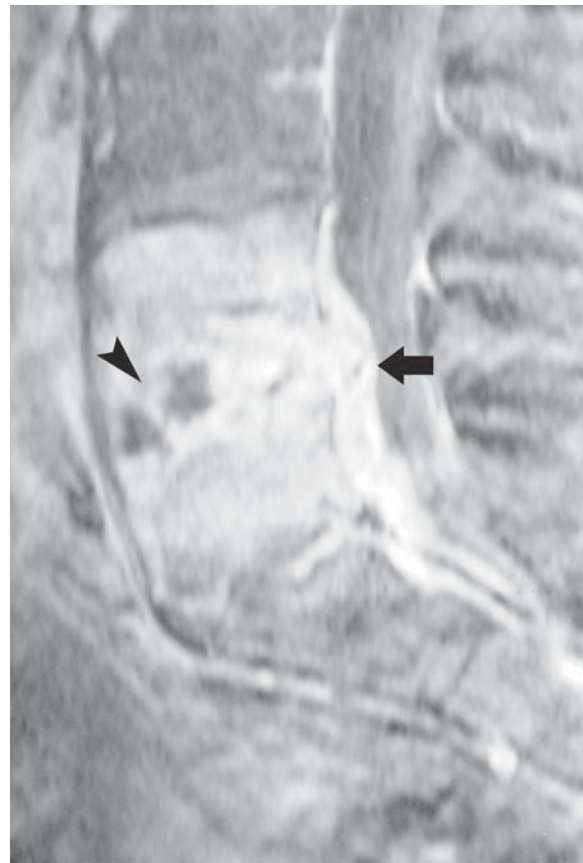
Discitis and osteomyelitis. Sagittal postcontrast T1-weighted fat suppressed image shows a peripherally enhancing L4–5 disc abscess (*arrowhead*) with adjacent enhancement of the infected L4 and L5 vertebral bodies and erosion of the adjacent endplates. Enhancing ventral epidural tissue (*arrow*) represents epidural phlegmon.
